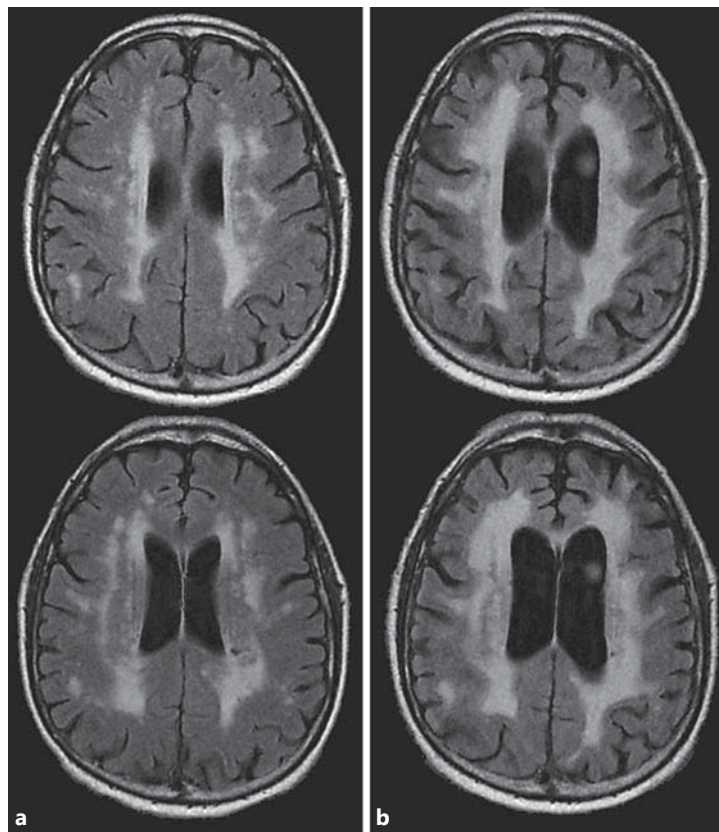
MRI axial FLAIR images of one patient at baseline (a) and 10 years after (b) show clear progression of WMLs in the frontal caps and bands of the periventricular region.
